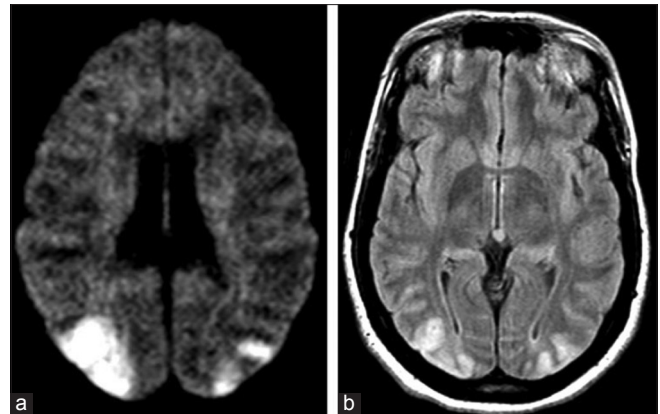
Complete (irreversible) cerebral infarctions in a 24-year-old woman who developed cortical blindness after difficult labor. (a) Axial diffusion-weighted magnetic resonance imaging (MRI) shows restricted diffusion in both occipital lobes, primarily in the arterial watershed zones. (b) Axial fluid-attenuated inversion recovery MRI shows corresponding edema and mass effect
